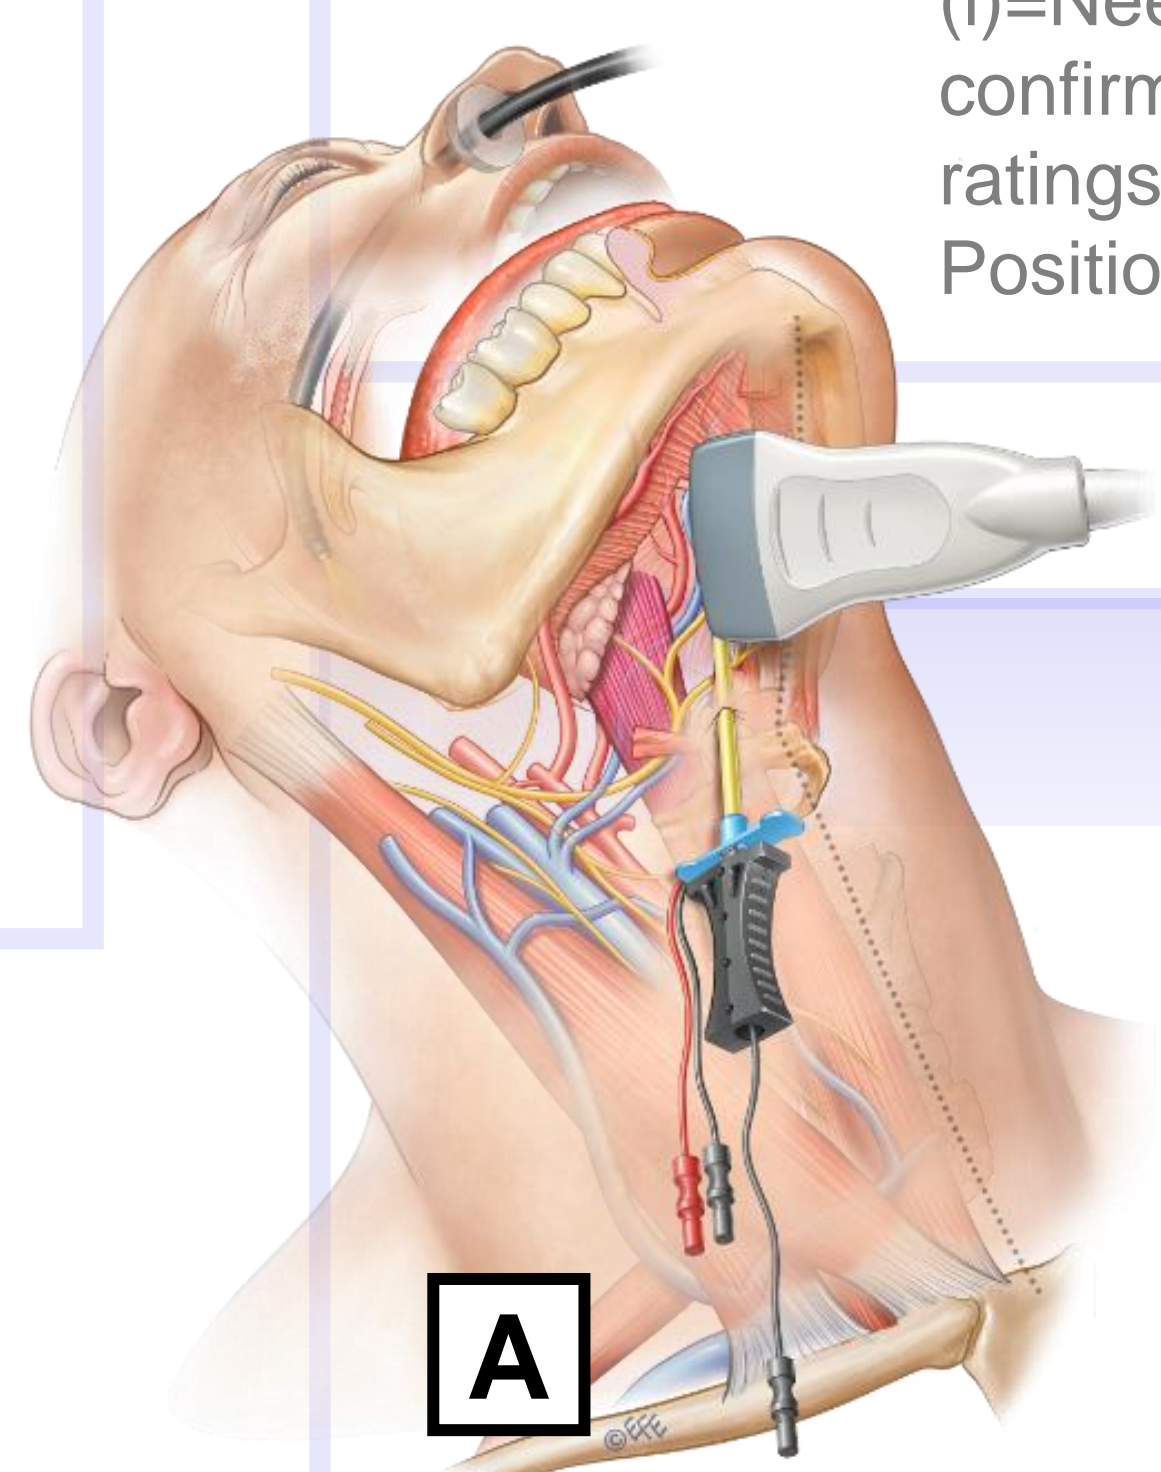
(A) Introducer and ultrasound probe. © Levant Efe. (B) Sonogram with annotations. MH=Mylohyoid; GH=Geniohyoid; GG=Genioglossus. (C) Sonogram with needle targeting HGN in view.
